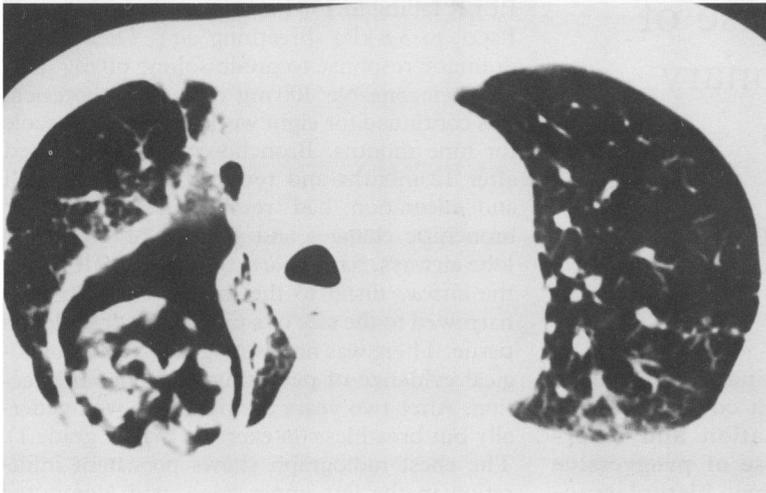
Computed tomographic scan of the chest demonstrating a rounded mass in the dependent portion of a large cavitation within the posterior part of the right lung.
